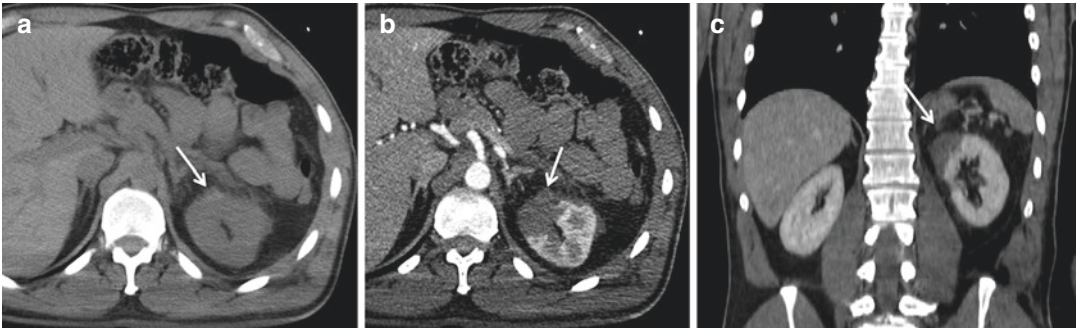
Renal contusion seen on MDCT. Unenhanced CT scan (a) shows an iso-hyperdense area, which is better delineated on post-contrast images (b) and coronal reconstruction (c) as a hypodense area
